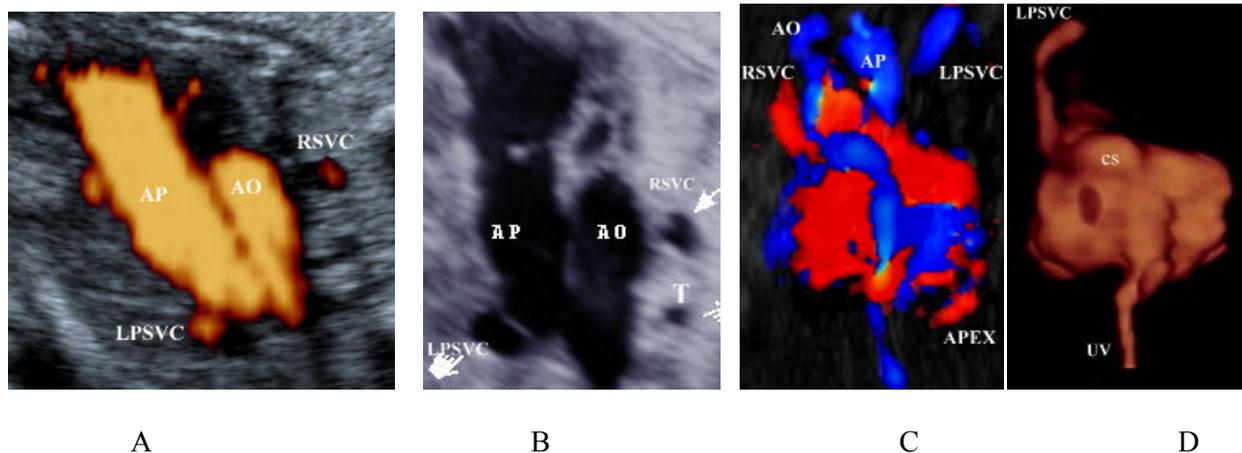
A, B and C: Four vessel view showing a left persistent superior vena cava (LPSVC). D: 3D power Doppler ultrasound showing the LPSVC drains into the dilated coronary sinus and to the right atrium. RA, right atrium; Left ventricle, right common carotid artery; RV, right ventricle; SVC, superior vena cava; T, trachea; Ao, aorta, PA, pulmonary artery, RSV, right superior vena cava, LPSVC, persistent left superior vena cava, RA, right atrium, UV, umbilical vein, CS, coronary sinus.
